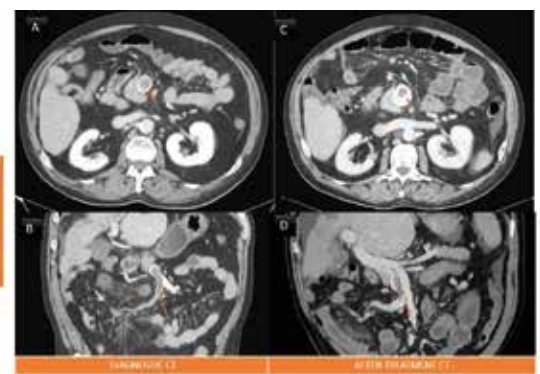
Contrast-enhanced abdominal CT in portal phase. A) and B) coronal views. C) and D) showing the luminal filling defect in splenic vein (arrow), extending to superior mesenteric vein. The thrombotic segment (arrowheads) is seen after oral contrast administration (arrow).
